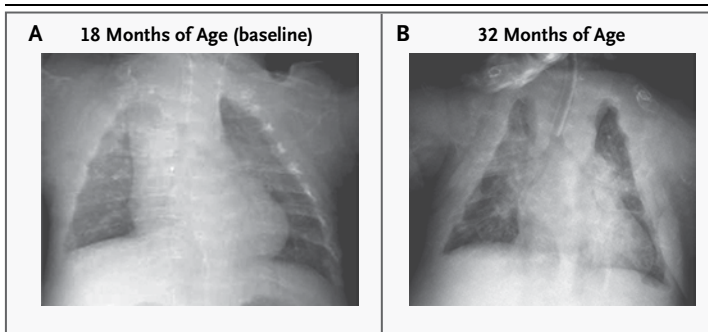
Radiographic Findings in Patient 4.
